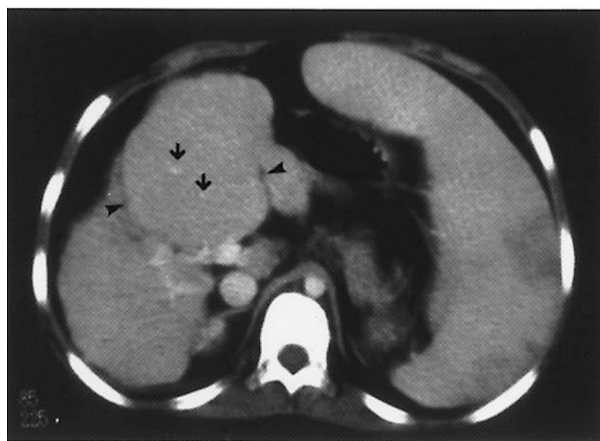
Contrast-enhanced CT shows enlargement of the medial segment (arrowheads) with penetration of vessels (arrows) and shrinkage of other segments of the liver. Splenomegaly is also demonstrated.
